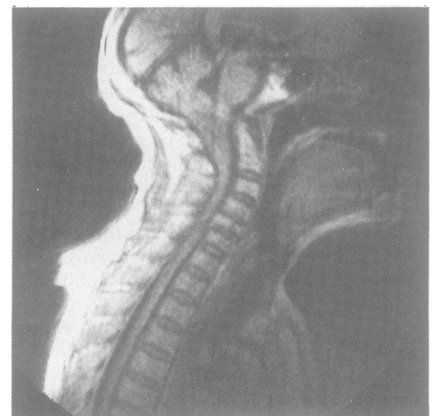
Figure Sagittal MR image.
